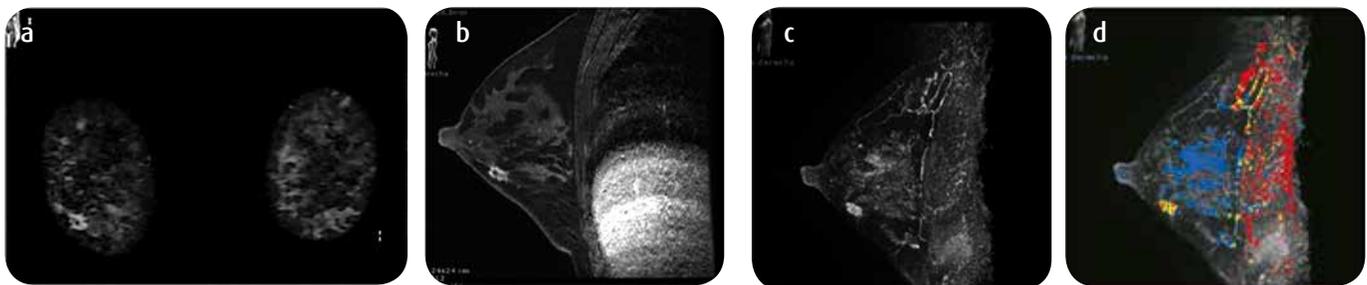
Patient of 47 years with diagnosis of infiltrating ductal carcinoma located in the meridian of the 8 hours in the right breast. a and b) coronal and sagittal MRI sequences with T2 information with fat saturation; and functional sequences with contrast medium c) sagittal and d) 3D reconstruction MIP with CAD system. Irregular mass, spiculate and with nodular enhancement in ring.
